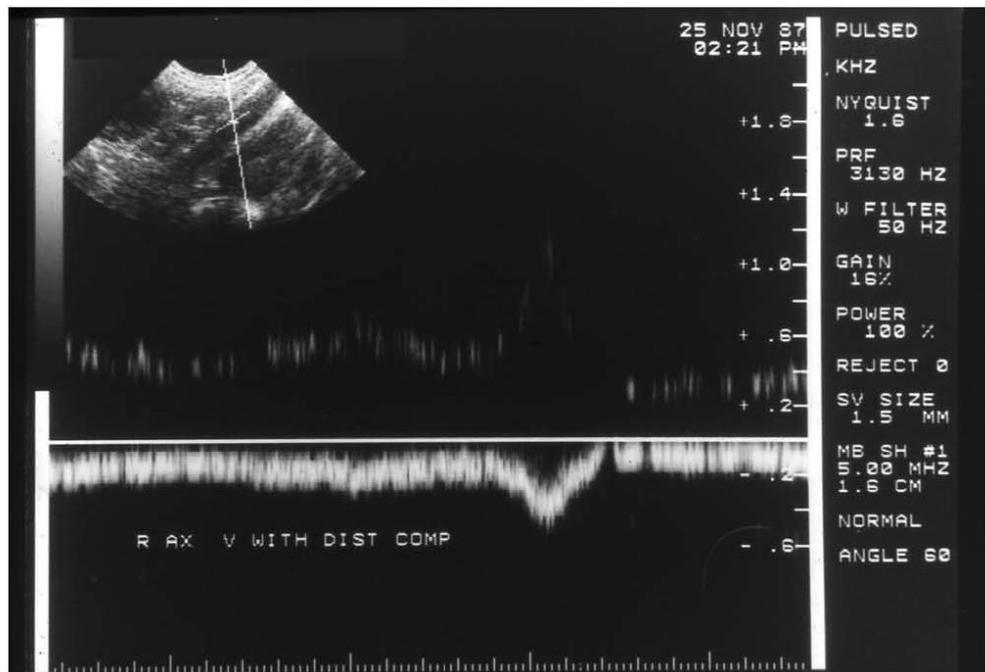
An ultrasound of the subclavian vein is obtained showing complete lack of pulsatility in the tracing with the flat straight line. The only deflection is the result of manual compression of the vein.
